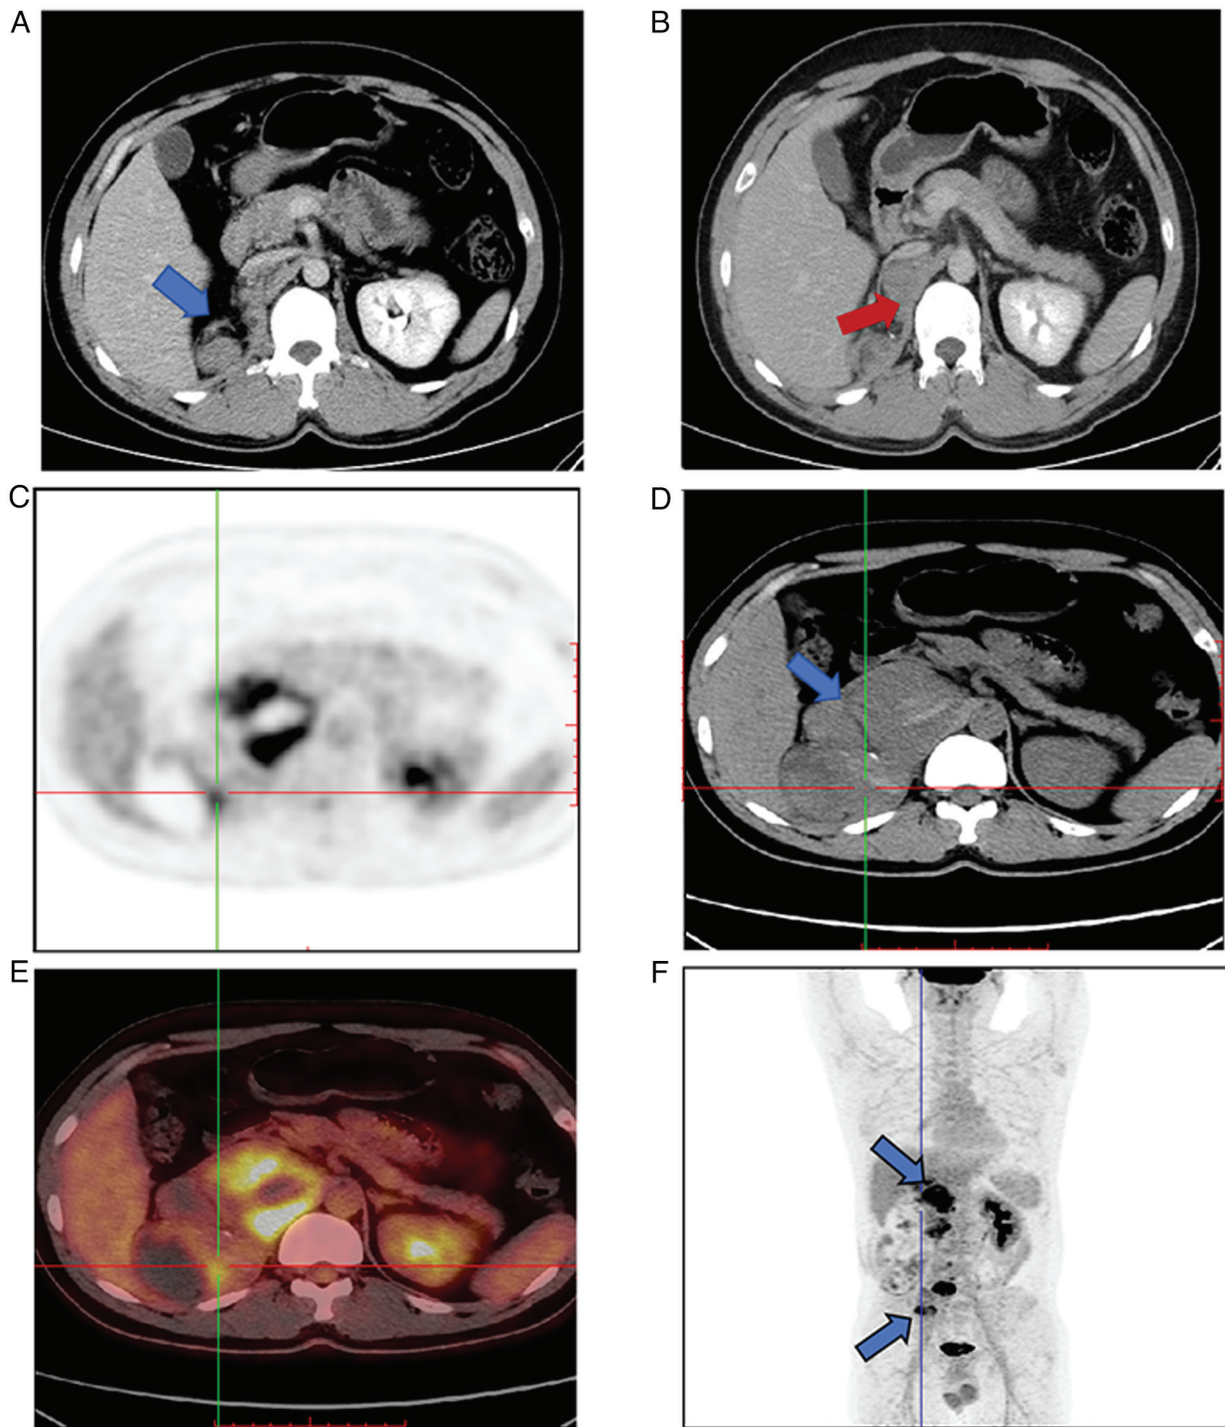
Post-operation abdominal enhanced CT and PET-CT findings. A total of three months post-operation, an abdominal enhanced CT reveals: (A) a nodule (blue arrow) in the right renal region, and (B) a nodule (red arrows) in the surgical area. PET-CT indicates post-radical nephrectomy for right kidney cancer with (C) abnormal radiotracer uptake. Additionally, (D) multiple cystic-solid irregular soft tissue density nodules and masses (blue arrow) are observed in the surgical area, with clear borders encasing the inferior vena cava. (E) The anteromedial aspect of the mass shows hypermetabolism. (F) The solid portions of both the renal region mass and the psoas major muscle mass also demonstrate abnormal radiotracer uptake (blue arrow).
